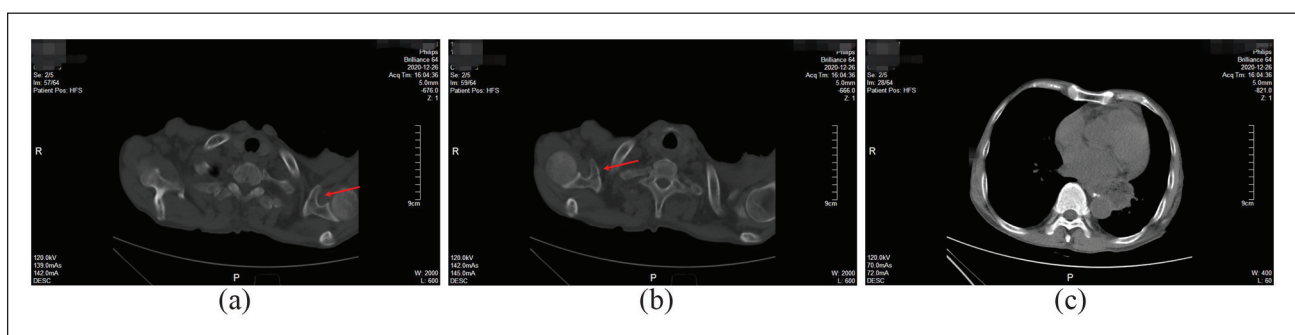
CT scan on 26 December 2020, used to evaluate lung condition before hip surgery. It shows that the bilateral coracoid process was continuous (a and b, red arrows) with no sign of fracture and no pleural effusion (c).
